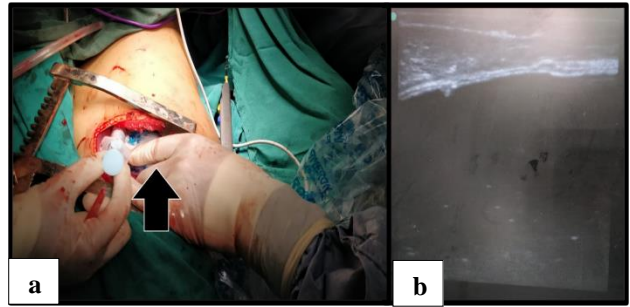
(a) Performing transdiaphragmatic intraoperative ultrasound (arrow represents ultrasound probe covered in sterile plastic cover inserted via Right posterolateral thoracotomy incision); (b) transdiaphragmatic ultrasound showing pericyst with homogenous cystic content underneath.
